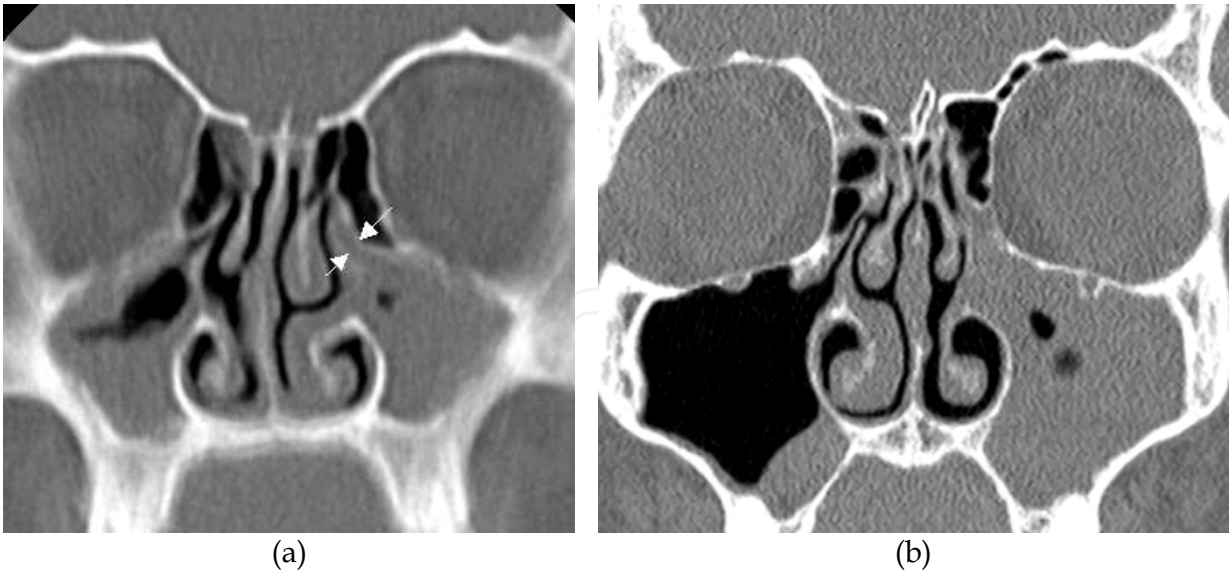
(a) Coronal CT shows infundibular inflammatory pattern with bilateral opacification of the maxillary sinuses due to obstruction of mucociliary drainage at the level of the ethmoid infundibulum (arrows). (b) Coronal CT shows unilateral left sided infundibular inflammatory pattern, and sporadic mucosal thickening in the right maxillary sinus floor.
